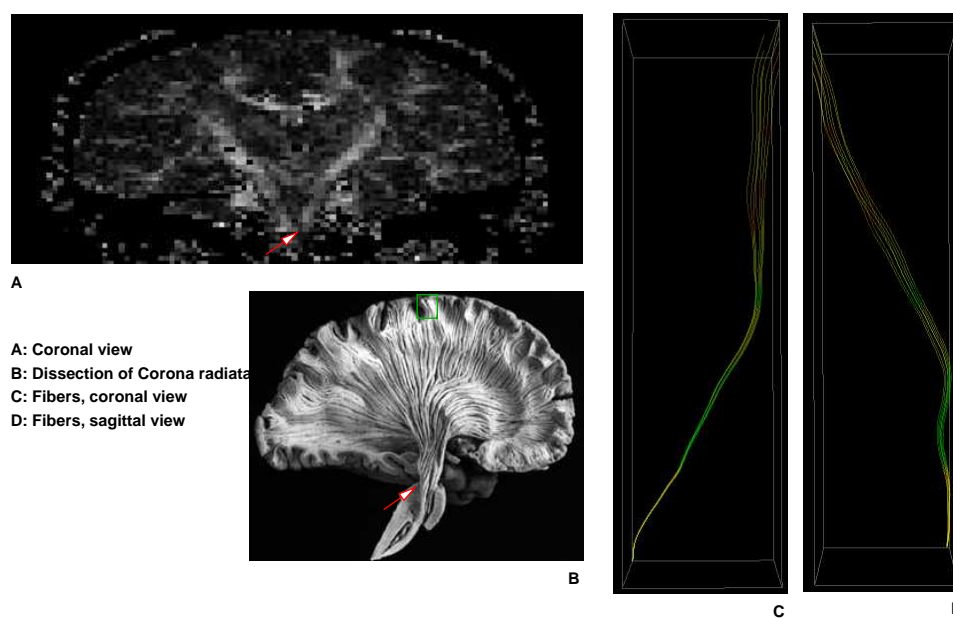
Diffusion MRI: Geodesics in the *corona radiata* (dissection image from [64])
